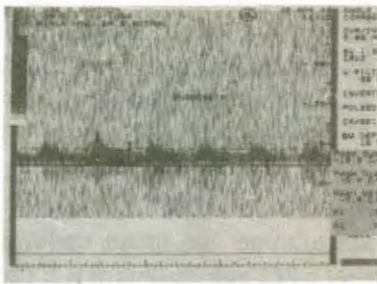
Pulsed Doppler Velocimetric Tracing of Endometrial Artery.
